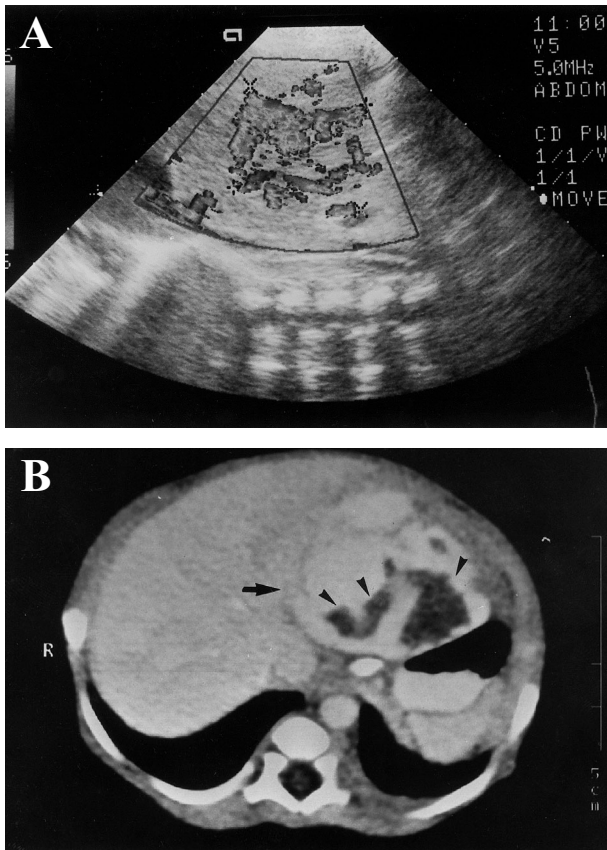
(A) Doppler ultrasound showing a hyperechoic mass (4.7 × 3.5 cm) with prominent vascularity in the left lobe of the liver. (B) Abdominal computed tomography with contrast disclosing a well-enhanced mass (arrow) with irregular central low-density cysts (arrowheads) in the left hepatic lobe compatible with a hepatic hemangioendothelioma. (C) Abdominal computed tomography with contrast demonstrating marked regression of the hepatic mass with a calcified lesion (arrowhead) in the left hepatic lobe with no evident cystic part or low-density component around the lesion.
